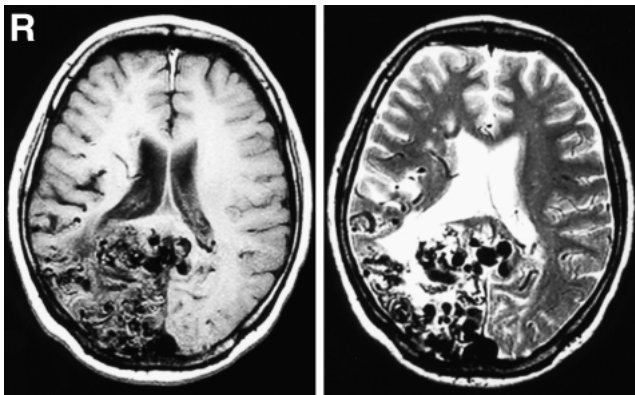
Case 1. Brain T₁- (left) and T₂-weighted (right) magnetic resonance images showing flow voids in the whole right occipital lobe and enlarged draining veins in the retrosplenial region. The medial wall of the trigone of the lateral ventricle was compressed by the extension of the nidus to the major forceps of the corpus callosum.
